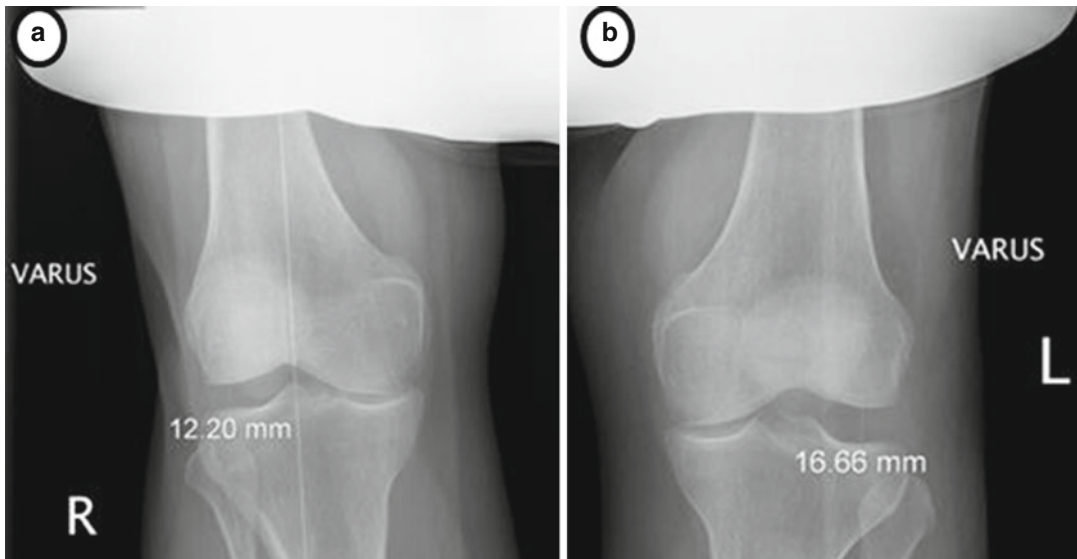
Varus stress radiographs demonstrating a side-to-side lateral gap difference of 4.4 mm, indicating a high likelihood of a grade III PLC injury. (a) This image shows
